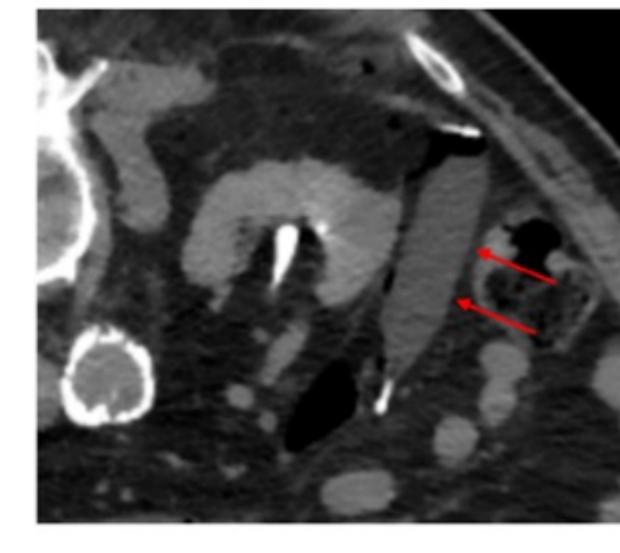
CT demonstrates balloon placement with sufflation of an 18 mm x 40 mm Atlas balloon (arrows) between the kidney and a loop of bowel. The tumor-to-bowel distance is 24 mm after inflation of the balloon catheter.
